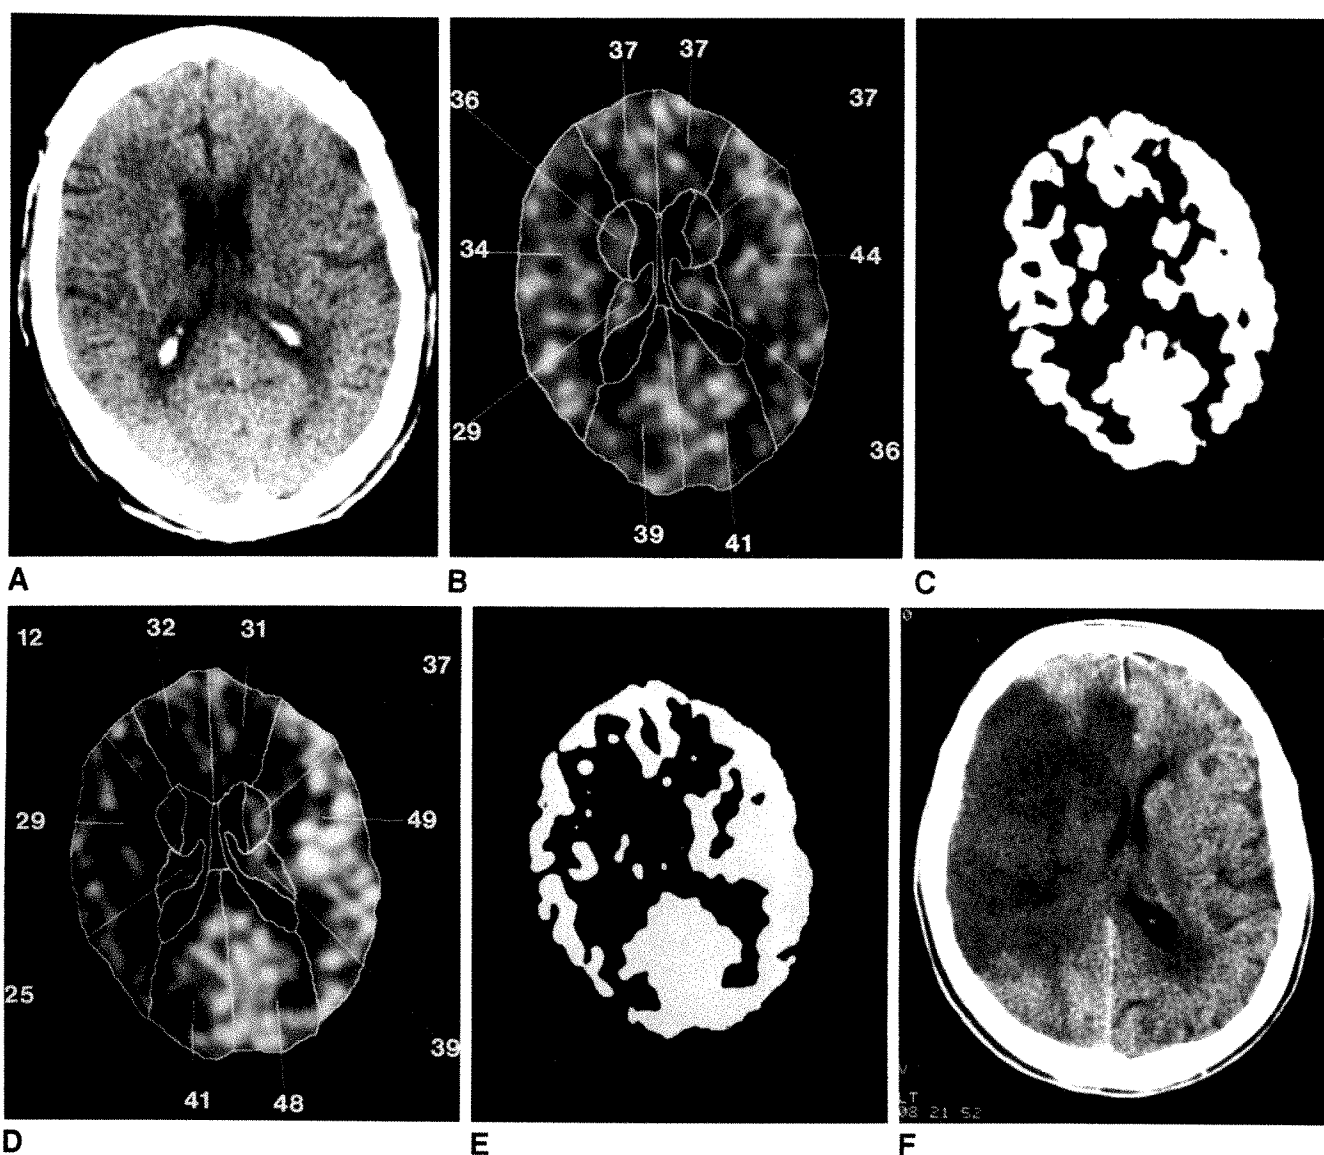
A–F, Case 29. Xe/CT scans demonstrate a representative type III scan series.
